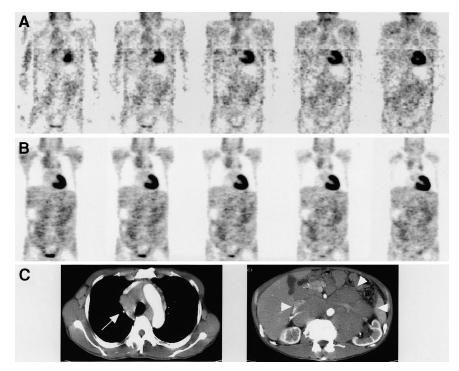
Patient 12, with indolent, low-risk lymphoplasmacytic lymphoma. Images obtained by both coronal FDG hybrid PET (A) and dedicated PET (B) show only faint uptake at sites that CT (C) shows to have numerous bulky lesions. Lesions extend from cervical to inguinal regions, including mediastinal (arrow) and para-aortic (arrowheads).
